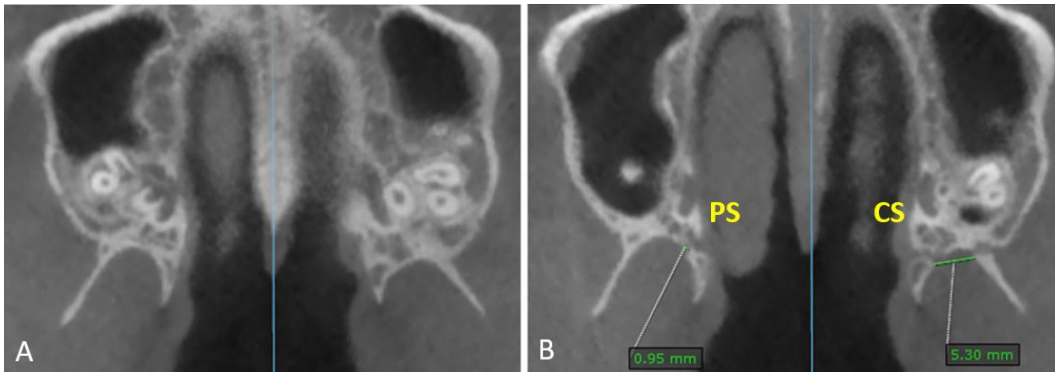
CBCT of a treated patient. A: pre-expansion. B: post-expansion. Openings between the lateral and medial pterygoid plates detected on an axial slice situated slightly above the axial palatal section (APS) in the post-expansion CBCT. PS: partial split of the pterygopalatine suture; CS: complete split of the pterygopalatine suture ^{36,44}.
